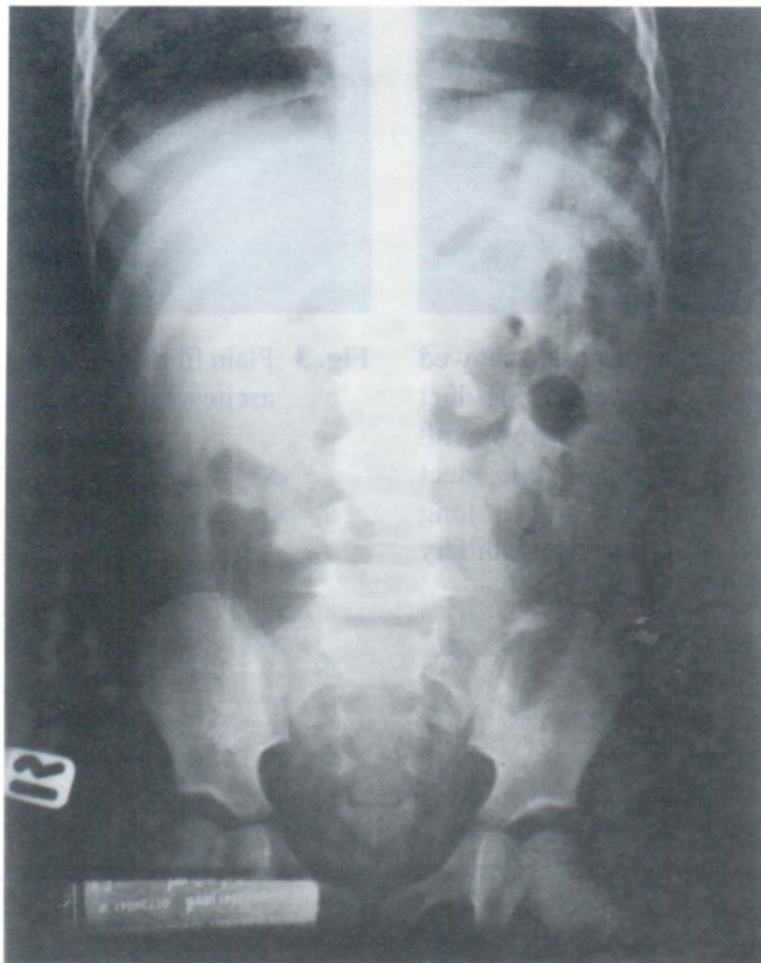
Plain film of the abdomen in case 2 showed bowel ileus.
